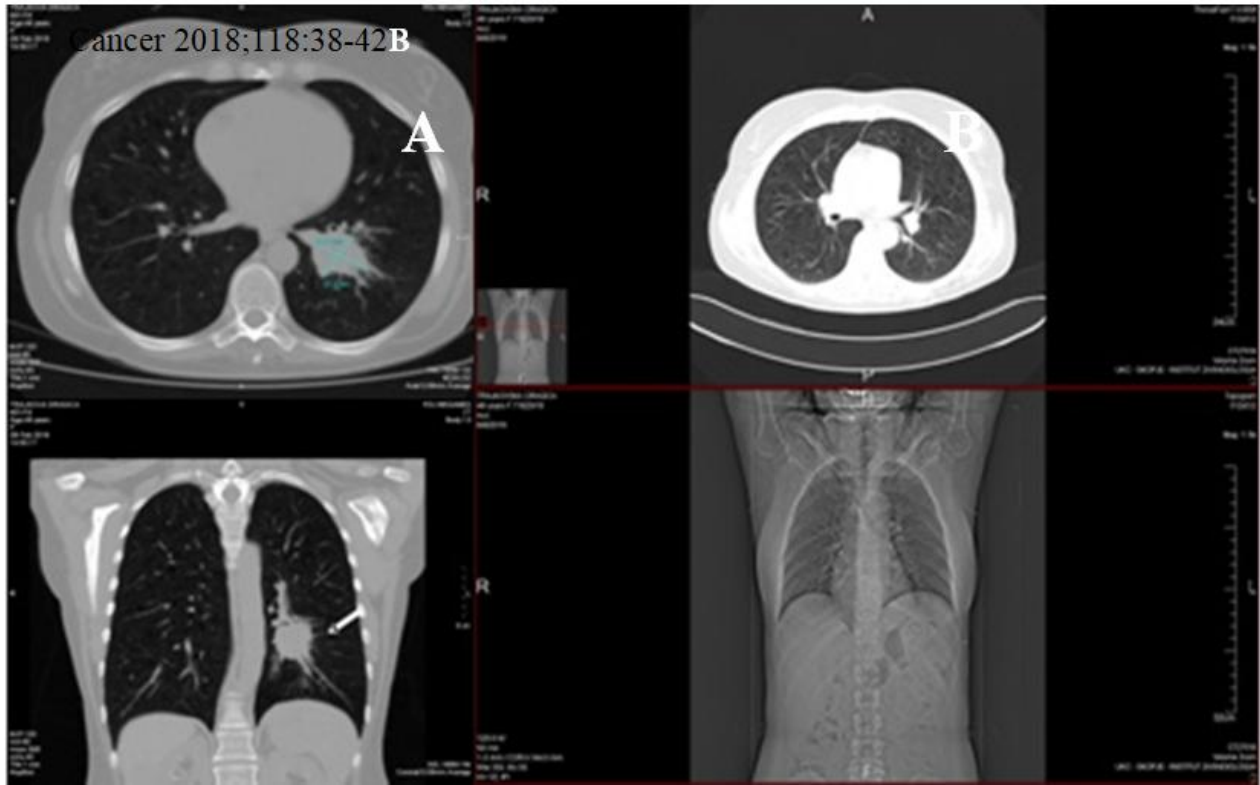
Computed tomography scans depicting the tumor response at the inferior left lung lobe, 9 months after alectinib treatment (A pretreatment lung foci, B positive response to the alectinib after 9 months)
